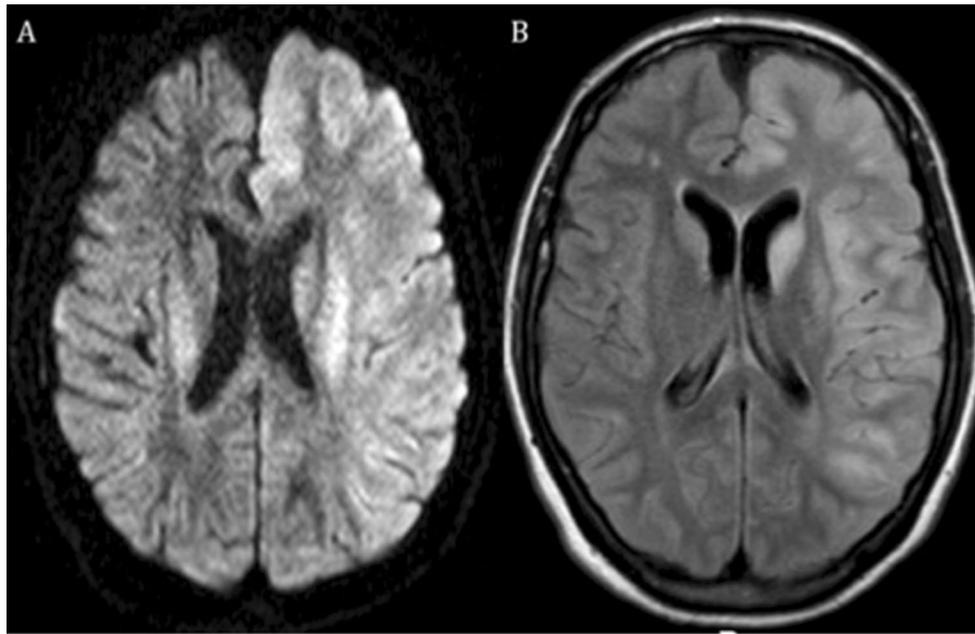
Axial brain MRI scan showing left carotid artery territory ischaemic change on the T1 (a) and flair (b) sequences
